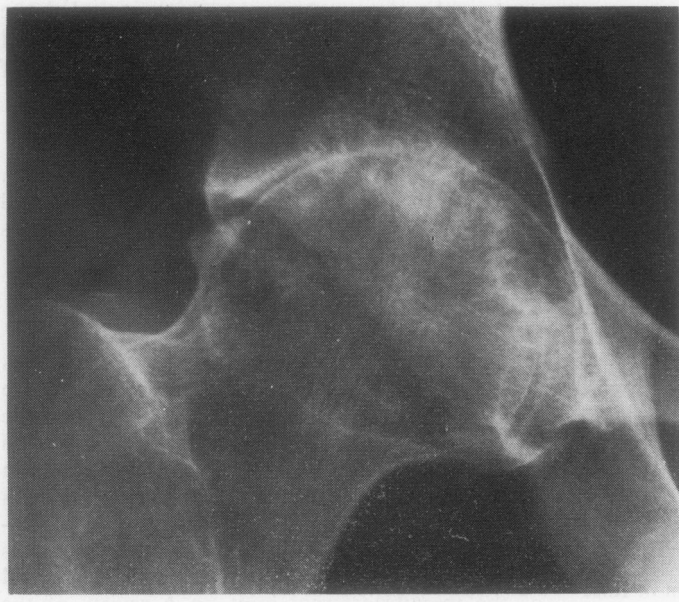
Case 3. Radiograph of the hip showing severe loss of cartilage joint space around the femoral head with erosive change.*
